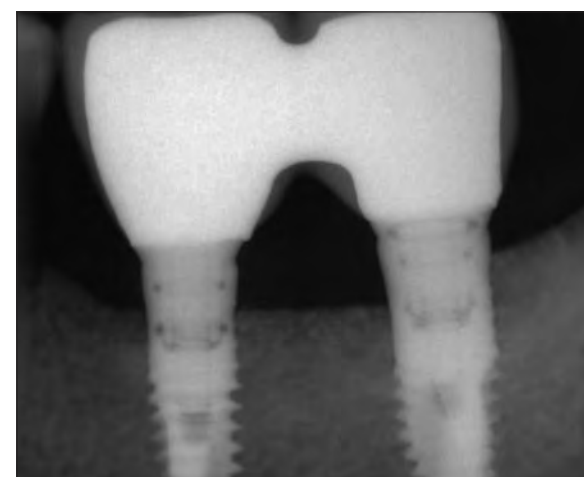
Radiographic control at 15 months: peri-implant bone levels are maintained.
